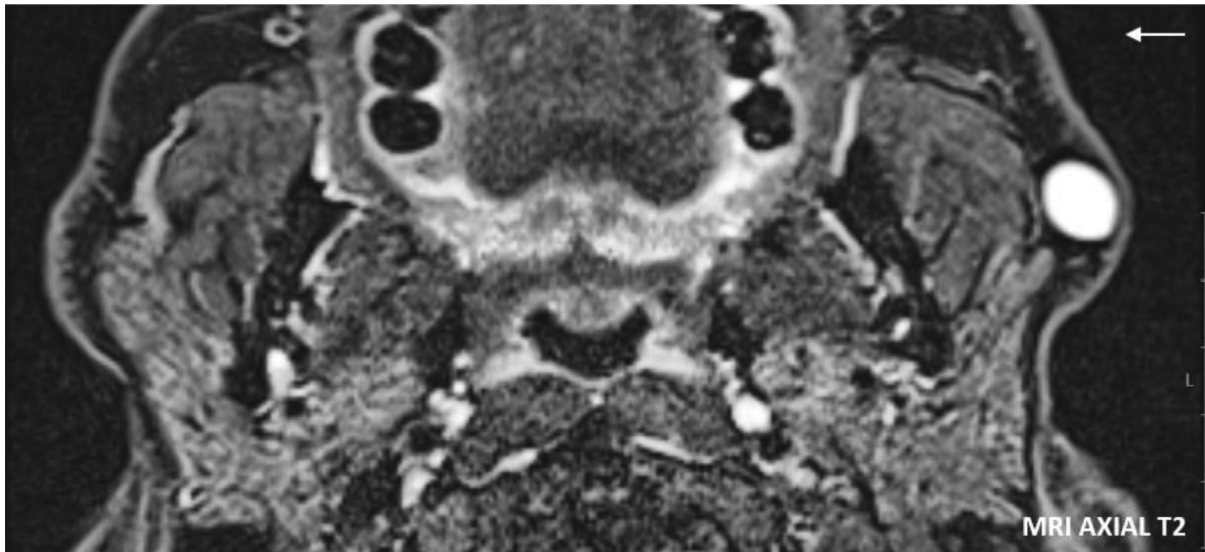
MRI: Axial T2 fat-saturated sequence. A well-defined T2 hyperintense subcutaneous lesion in the left parotid region.
